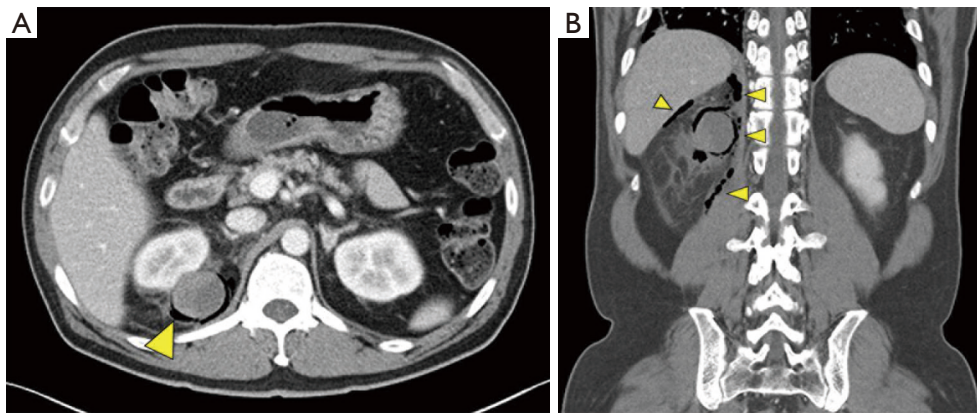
Abdominal CT scan showed focal low attenuation lesion in the right kidney with about 3 cm exophytic high attenuated lesion in the right kidney upper pole (yellow arrow) (A). Gas-containing fluid collection within the retroperitoneal space was revealed (yellow arrows) (B). CT, computed tomography.
